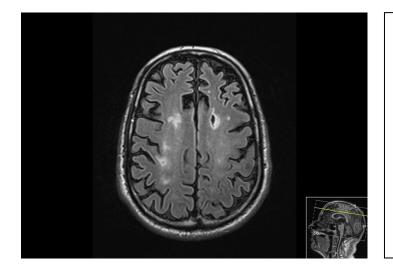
shows one of the MR images taken from one of the patients in the study with ischaemic stroke in frontal white matter regions. A total of 61% of the study participants had ischaemic changes in frontal parts of the brain.
